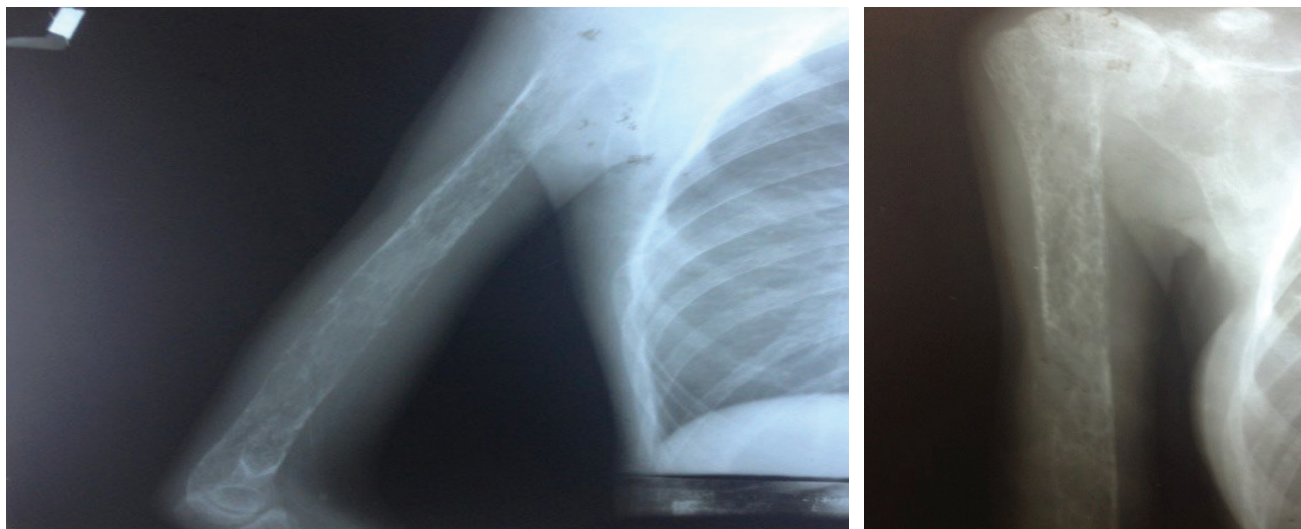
X-ray of the right humerus showed generalized decrease in bone density and subperiosteal and intracortical resorptive changes. Most of the humeral shaft demonstrated a mottled multicystic appearance with prominent trabeculations. A fracture was seen on the middle third of the humerus.
